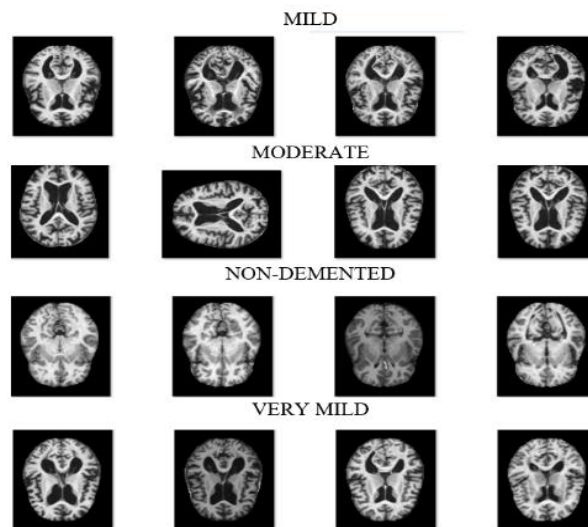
Sample MRI data from the dataset
